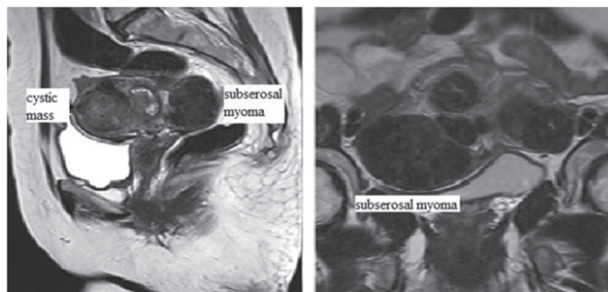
• The cystic mass and subserosal LMs in the MRI.
